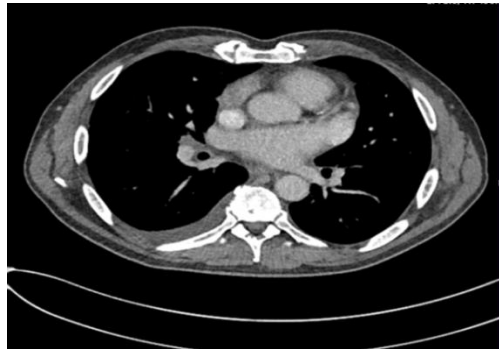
CT of Thorax and Abdomen with Contrast 07/09/2024
